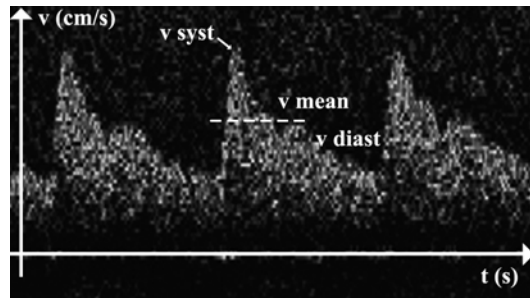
The Doppler spectrum and its characteristics: v_{syst} : systolic peak velocity; v_{mean} : mean velocity; v_{diast} : end diastolic velocity
